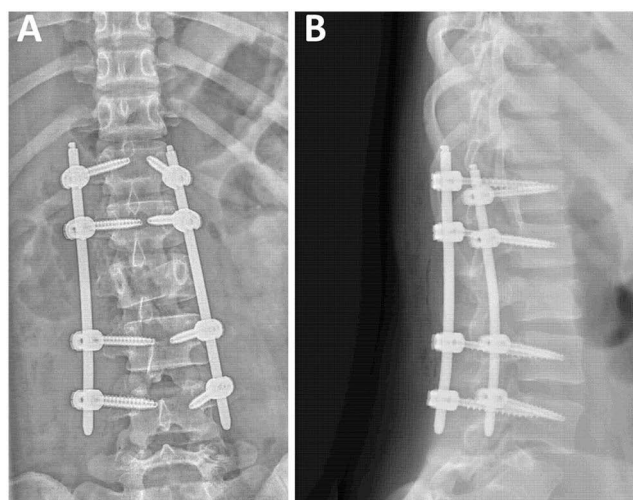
Postoperative thoracolumbar spine radiographs. (A) Anteroposterior view. (B) Lateral view demonstrating L2 fracture fixation and decompression.
